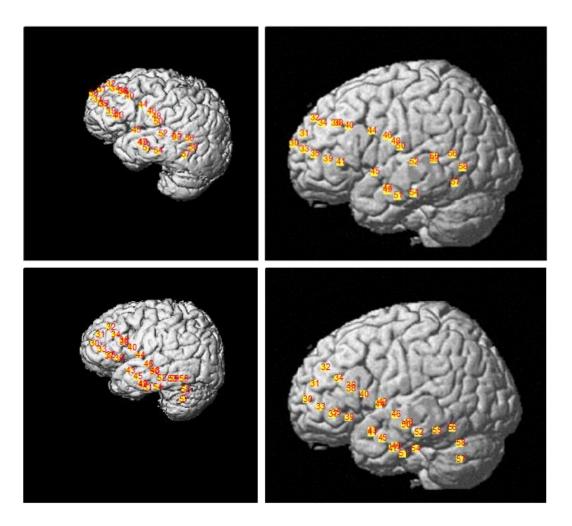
Here there are 2 examples of the incongruent co-registration of the optodes on the cortex, resulting from different positioning of the head in the MRI scanner and head size. Left) native cortical space. Right) template MNI space.
